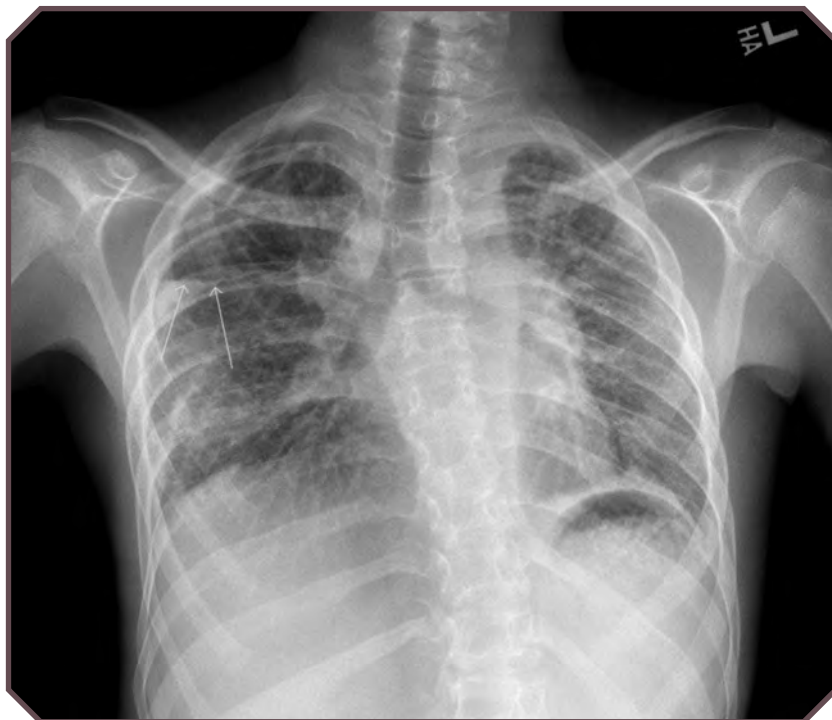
Frontal chest radiograph in a 15-year-old boy treated with chemotherapy and radiation therapy during infancy for a paraspinal embryonal rhabdomyosarcoma. Interstitial changes are shown, with bronchiectasis and small right apical pneumothorax, as well as kyphoscoliosis. (Arrows do not indicate a relevant finding.)
